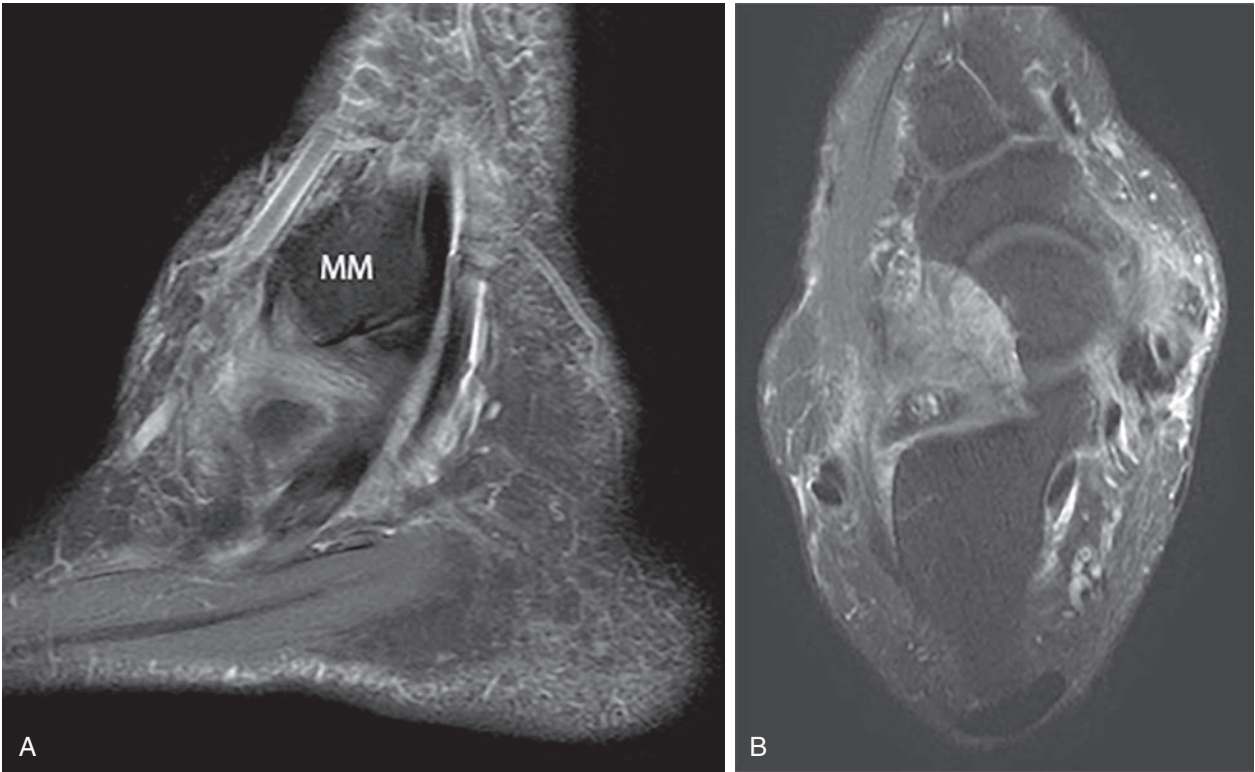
Magnetic resonance imaging (MRI) findings of posterior tibialis tendon dysfunction. (A) Sagittal view at the level of the medial malleolus (MM) demonstrating longitudinal void within the tendon. (B) Transverse view at the level of the talus also demonstrating degenerative tearing and thickening of the PTT with intratendinous voids and increased fluid around the tendon.
